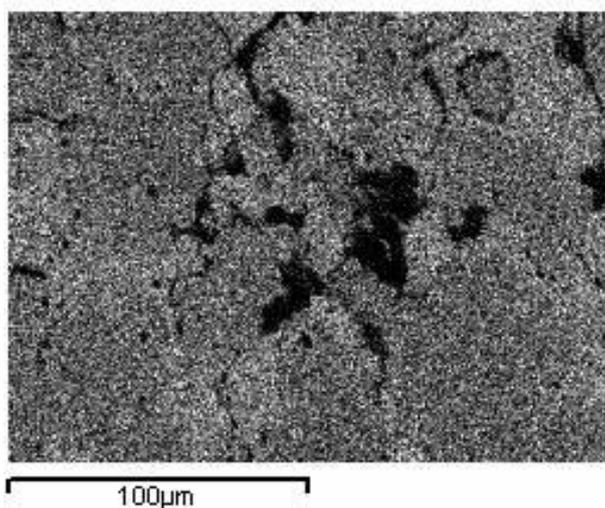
Zinc X-ray map of area of secondary cracking
